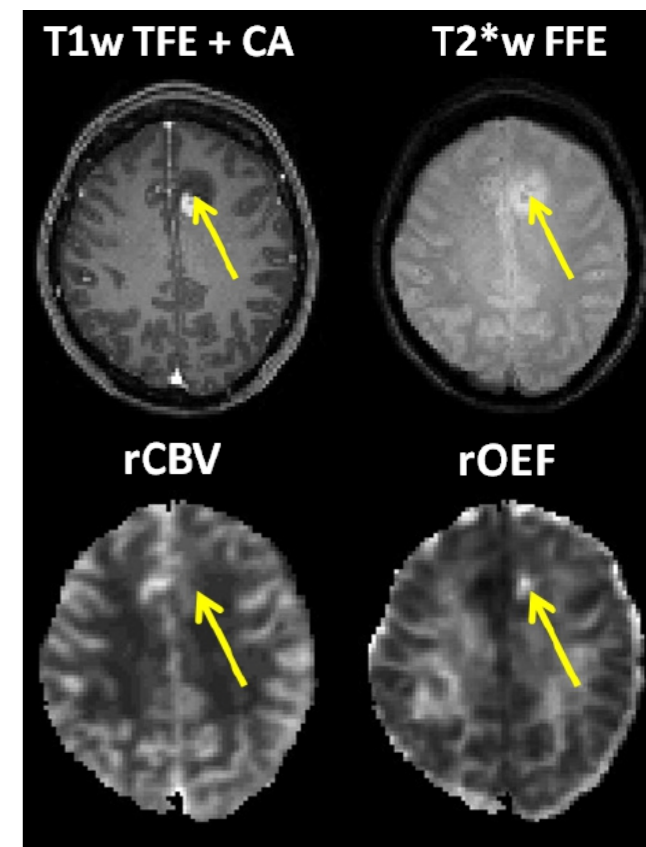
Single slice in a glioblastoma patient. The T1-weighted turbo field echo image after contrast agent application (T1w TFE+CA) shows partial CA enhancement in the tumor. A small hot spot marked by an arrow is visible in the relative oxygen extraction fraction (rOEF) map. Since it is located in a hyperintense region in the T2*-weighted fast field echo (T2*w FFE) image outside of edema and has moderate relative CBV (rCBV), it is a potentially hypoxic spot in non-enhancing tumor tissue. Figure from [6].
